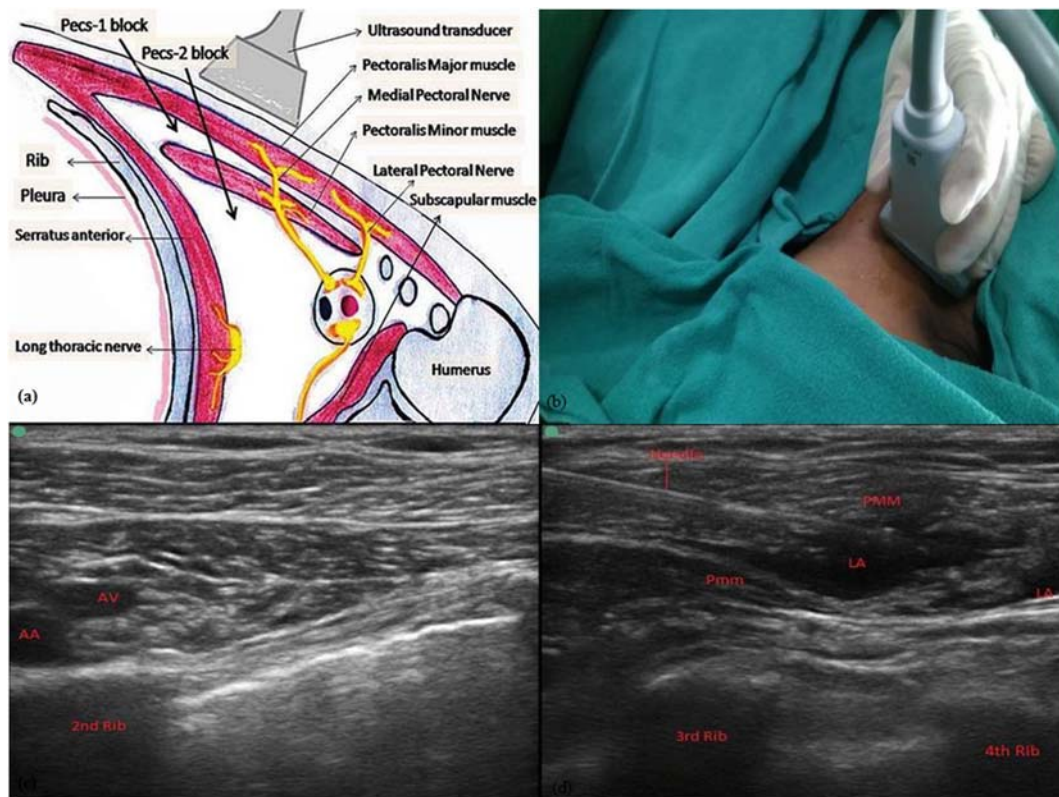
(a) Anatomical basis of pectoral nerves block (b) ultra sound probe position (c) ultra sonographic anatomy and identification of 2ndRib (AV-Axillary Vein, AA-Axillary Artery) (d) Pectoral nerve block I and II (PMM – Pectoral Major Muscle, Pmm – Pectoral minor muscle, LA - Local anesthetic).
